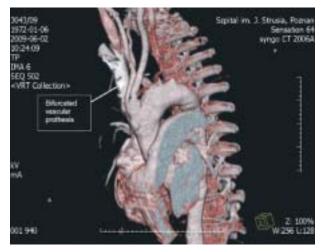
Multi-slice computed tomography revealing good patency of the bypass grafts
